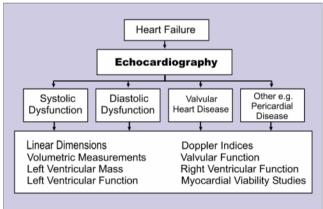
The role of echocardiography in heart failure.
